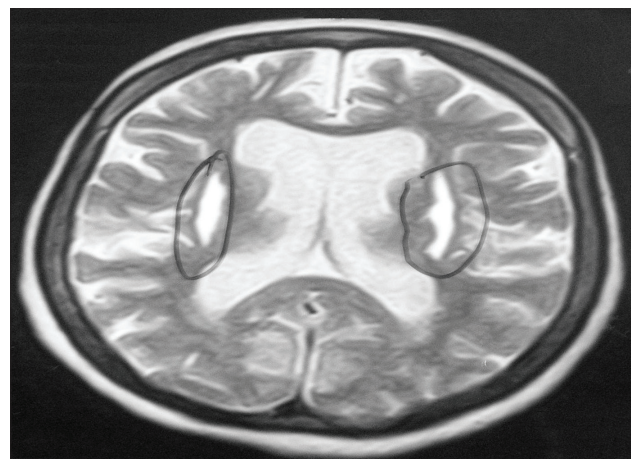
Magnetic resonance imaging of a patient with transdermal methanol intoxication. Bilateral symmetric putaminal necrosis and generalized cortical atrophy are seen which is typical of methanol intoxication
